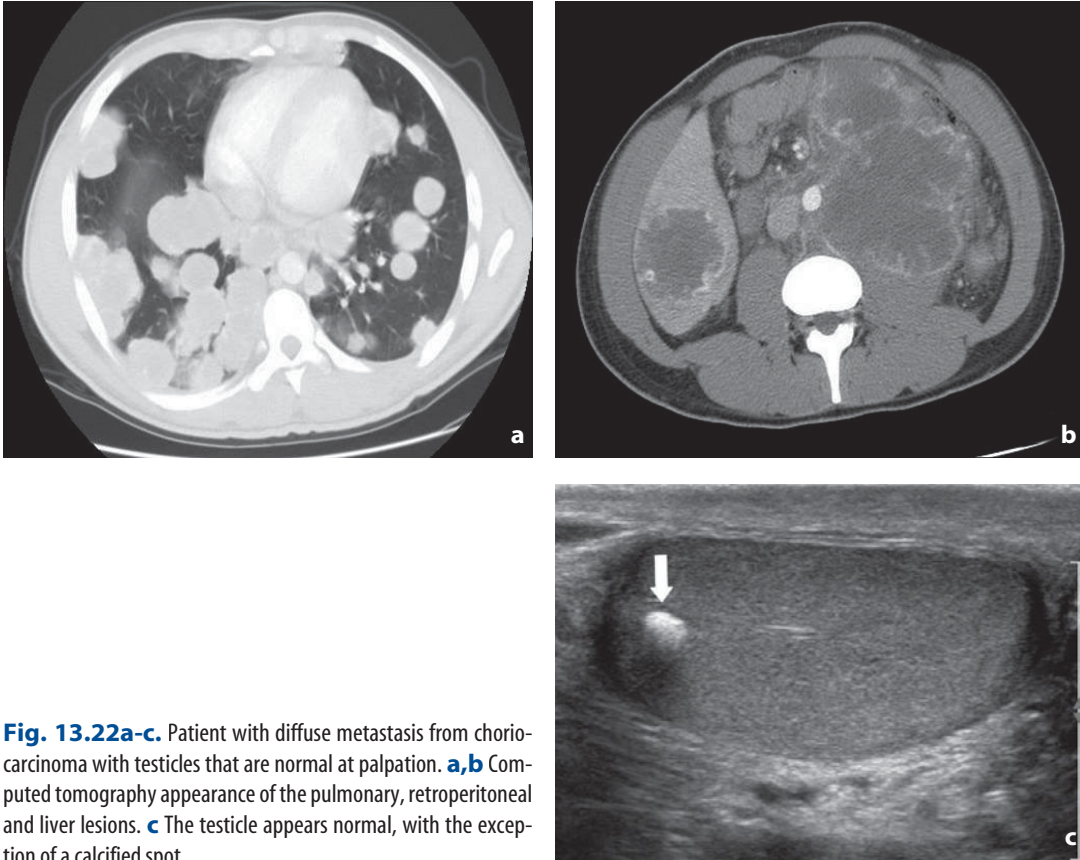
Patient with diffuse metastasis from choriocarcinoma with testicles that are normal at palpation. a,b Computed tomography appearance of the pulmonary, retroperitoneal and liver lesions. c The testicle appears normal, with the exception of a calcified spot
